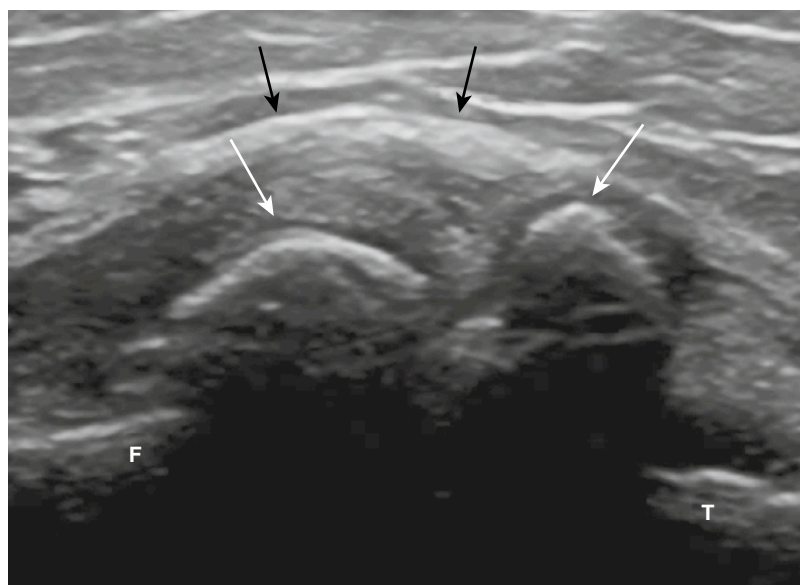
An osteoarthritic knee is assessed with ultrasound. The 12-MHz longitudinal scan over the medial aspect of the joint shows large osteophytes (*white arrows*) and displacement of the medial collateral ligaments (*black arrows*). F, femur; T, tibia.
